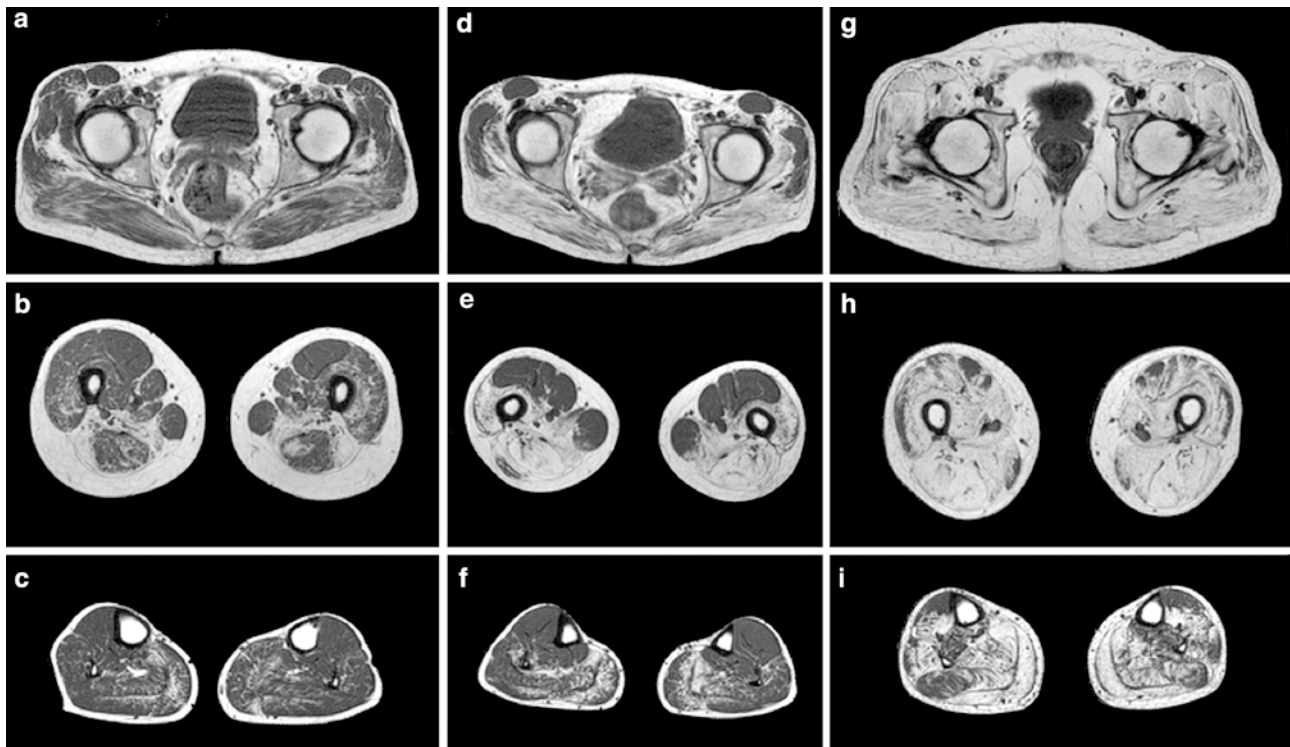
Axial T1-weighted MRI obtained from three LGMD 21 patients on the pelvic (a, d, g,) thigh (b, e, h) and lower leg (c, f, i) levels demonstrating different degrees of fatty muscle degeneration. The MRI findings correspond well with the clinical phenotype. In the mild clinical phenotype (a, b, c) the fatty degeneration is most obvious in the adductor and biceps femoris muscles. In the patient with a rather
